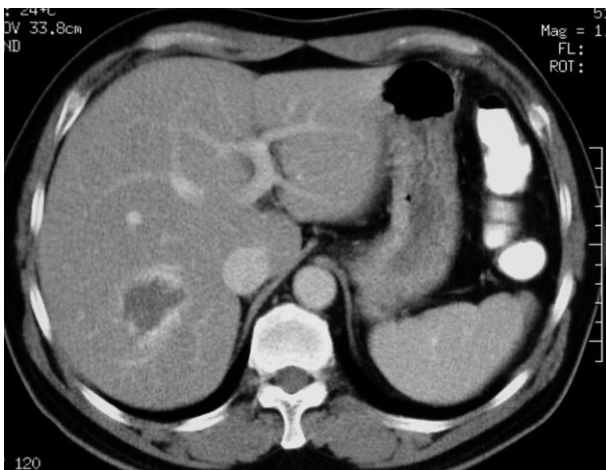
Venous phase CT image shows progressive enhancement from periphery of the hepatic mass. Note that equilibrium of contrast enhancement in the aorta and IVC.
